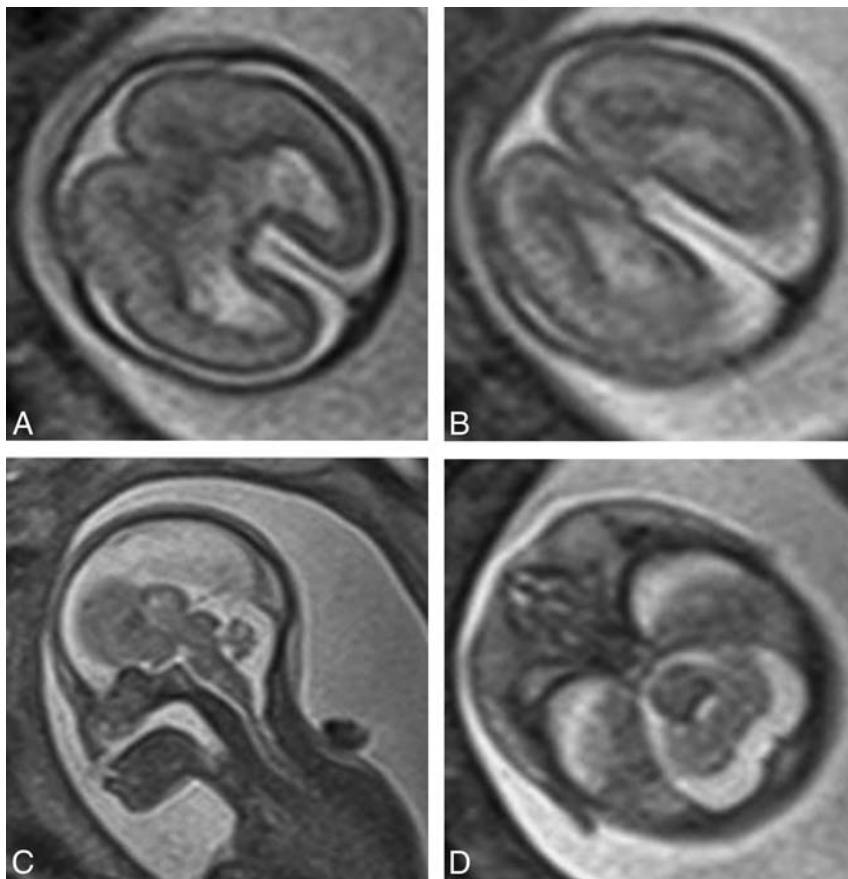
T2-weighted images (single-shot fast spin-echo) in a 24-week gestational age fetus with alobar holoprosencephaly according to the DeMyer classification and a severity score of 20/20 (case 2). Axial images of the supratentorial brain (A and B) show no attempt at formation of the interhemispheric fissure and a holoventricle and posterior cyst. Sagittal imaging (C) shows an abnormally kinked brain stem.
